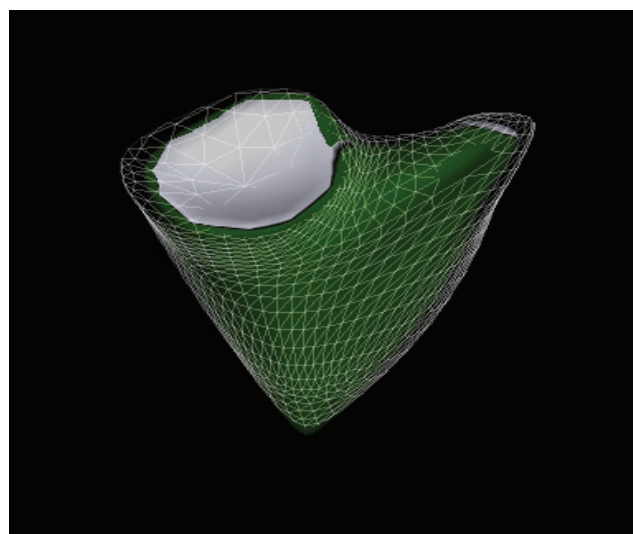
3D transthoracic echocardiography-right ventricle ejection fraction.
